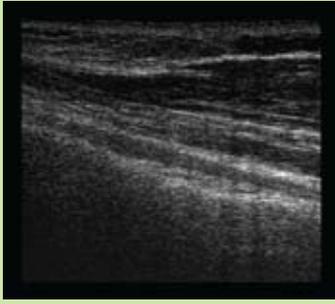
Longitudinal scan of the long head of the biceps, appearing falsely hypoechoic due to the angle between the ultrasound beam and the tendon fibers (anisotropic artifact).
